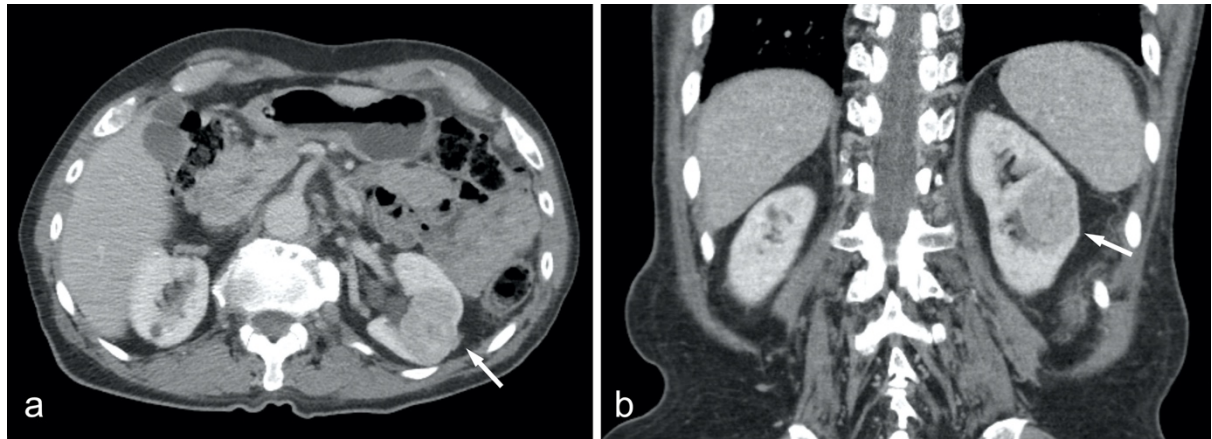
Contrast-enhanced axial (a) and coronal (b) CT plans in the nephrographic phase with a renal oncocytoma on the left kidney exhibiting a subtle central scar. Only 1/3 of renal oncocytomas display central scar, which makes a definite diagnosis difficult since RCC can also show central scar or central necrosis. (*Karolinska University Hospital Huddinge, MIDOR study*)
